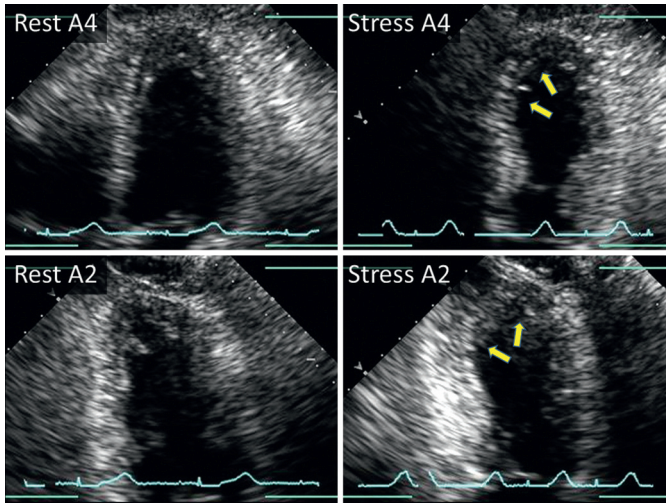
Stress echocardiography showing evidence of ischemia in the LAD distribution. Resting and stress echocardiograms in the apical four-chamber (A4) and apical two-chamber (A2) views reveal new severe mid to distal anteroseptal, apical, and distal inferior LV hypokinesis (arrows). This patient was found to have greater than 90% mid-LAD stenosis on cardiac catheterization.
